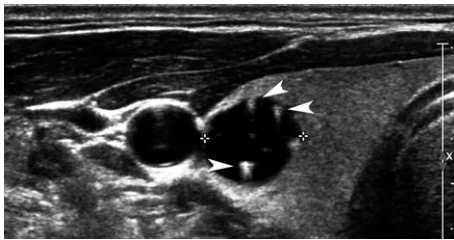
Colloid cyst. A 53 year old male with an incidental mass in the right lobe seen on CT. Transverse US shows a cystic mass in the right lobe with ring down artifact (arrowheads) seen in it consistent with a colloid cyst.
